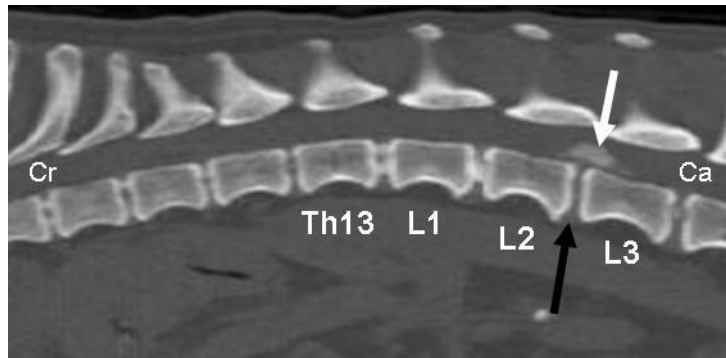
CT study of the thoracolumbar area reconstructed in the sagittal plane showing a narrowing of the intervertebral disc space of L2 and L3 (black arrow). Calcified disk material (white arrow) is present within the vertebral canal.
